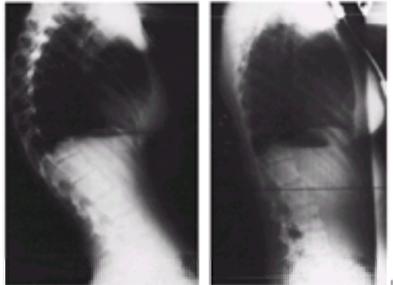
A: Radiographs of a 13-year-old boy who sustained vertebral end plate changes at several levels while playing football. Note the associated spondylolysis ( arrow) and mild spondylolisthesis. The patient's discomfort responded satisfactorily to bracing. B: The radiographs at age 17 years demonstrate the continued free fragment appearance of the vertebral apophysis at several levels and persistence of Schmorl's nodes.
